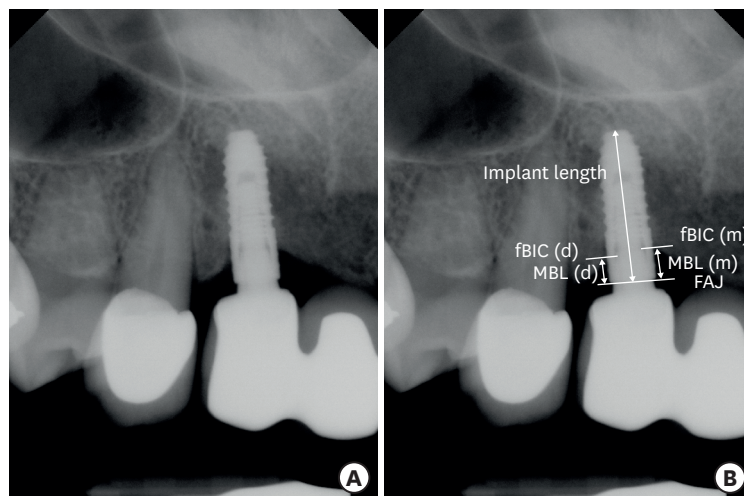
Methods of measuring the MBL of an implant. (A) Periapical radiograph of an implant showing the MBL. (B) Reference points for calculating the MBL. Implant length is used as a known value for calibration, and the MBL is determined by averaging the mesial and distal MBL. MBL: marginal bone loss, fBIC: first bone-to-implant contact, FAJ: fixture-abutment junction, (m) and (d): mesial and distal side, respectively.
